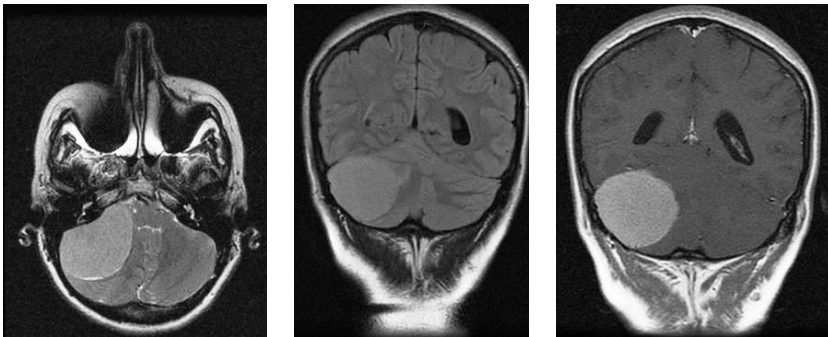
Posterior fossa meningioma. MRI T1 sequences.
